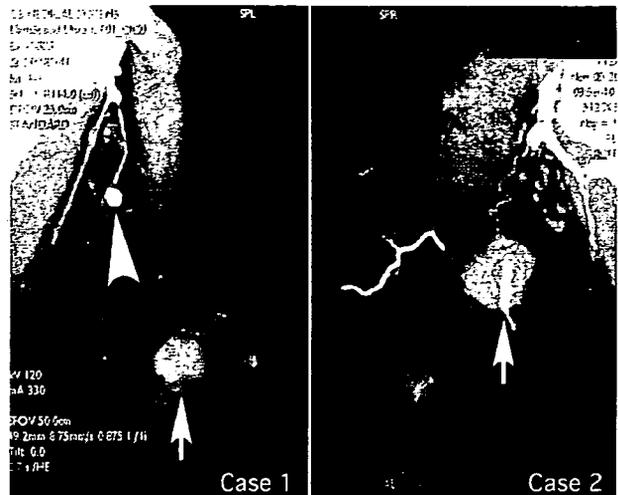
Three-dimensional CT revealed enhancing tumors (arrows) and an enhancing round shaped axillary lymph node (arrow head in case 1) suggesting metastasis.
